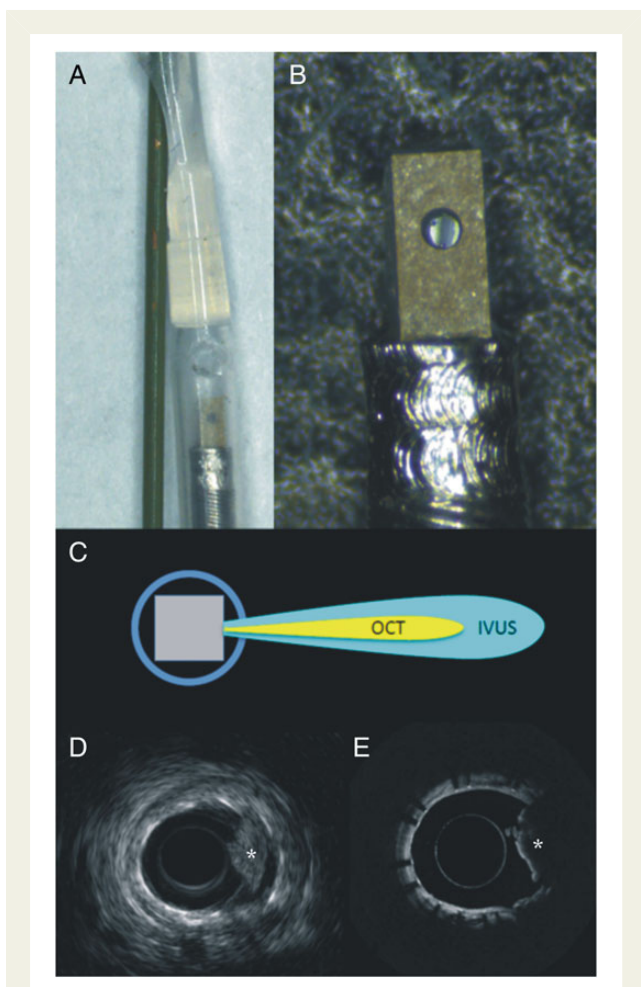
Dual mode intravascular ultrasound—optical coherence tomography catheter. The prototype has a diameter of 3 Fr with the optical coherence tomography component being integrated to the intravascular ultrasound probe (A and B). This design allows a collinear alignment of the two transducers (C), and thus accurate co-registration of the intravascular ultrasound (D) and optical coherence tomography (E) images (the asterisk indicates the presence of red thrombus).
